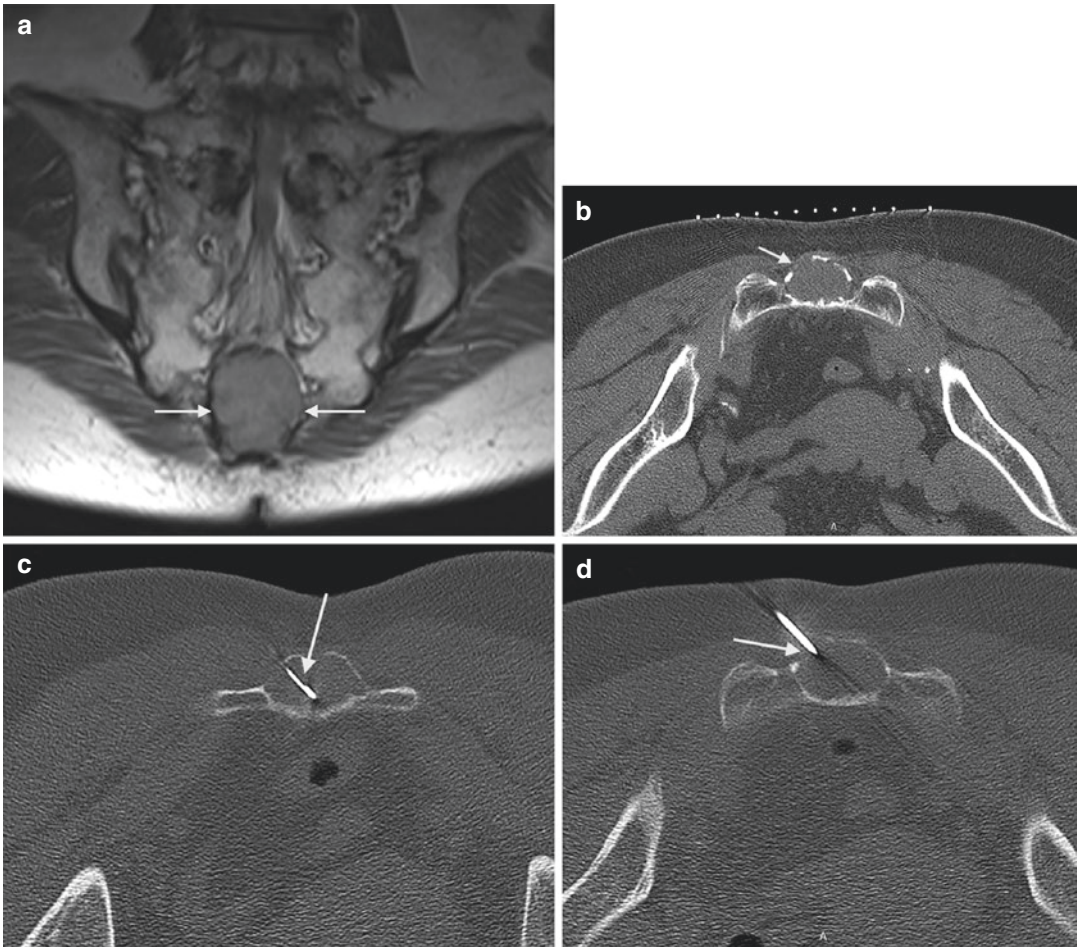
A 66-year-old female with a sacral lesion. T1-weighted coronal image (a) shows a midline expansile soft tissue mass within the caudal sacrum (arrows). Axial CT image (b) with skin grid in place shows the mass partially eroding the sacrum (arrow). Axial CT image (c) shows a guide needle inserted through the eroded portion
